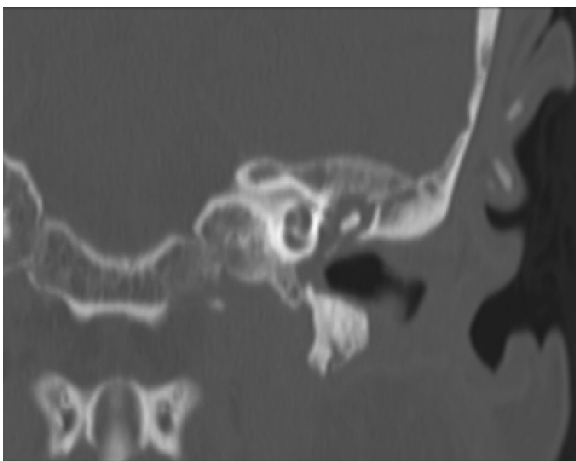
Coronal computed tomographic scan of the temporal bones shows inflammatory changes of the right middle ear and external auditory canal.
